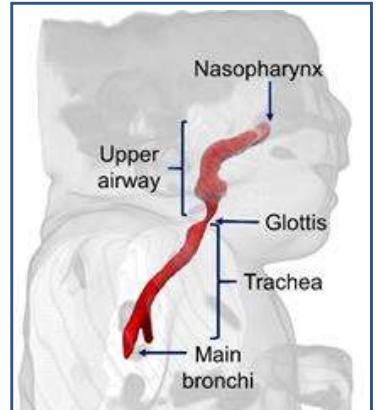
MRI at 40 weeks. Severe bronchopulmonary dysplasia and tracheomalacia. Preliminary model takes 1 min for airway auto segmentation.
